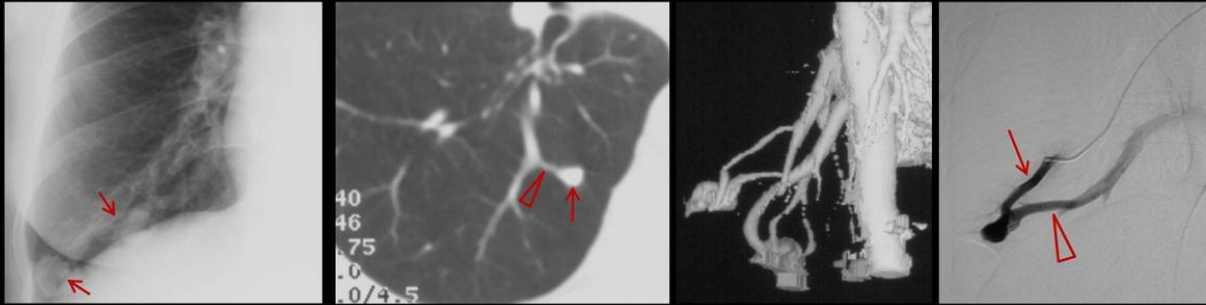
A 37 year-old patient with hereditary hemorrhagic telangiectasia has a chest radiography with some nodules in the right lung (a). Axial CT image (b) shows the feeding artery (arrowhead) of a small MAV (arrow). 3D reconstruction (c) shows the feeding and draining vessels. Pulmonary arteriography (d) of another patient showing a simple arteriovenous malformation supplied by a single artery (arrow) and drained by a single vein (arrowhead).
